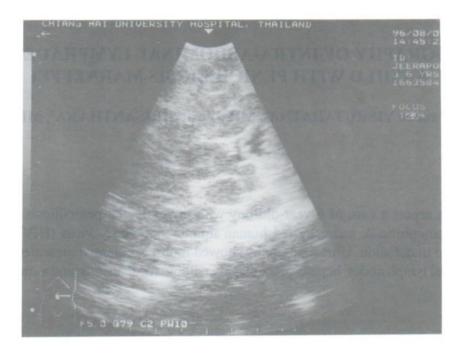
Transverse sonogram of left side abdomen shows multiple enlarged mesenteric lymph nodes.
